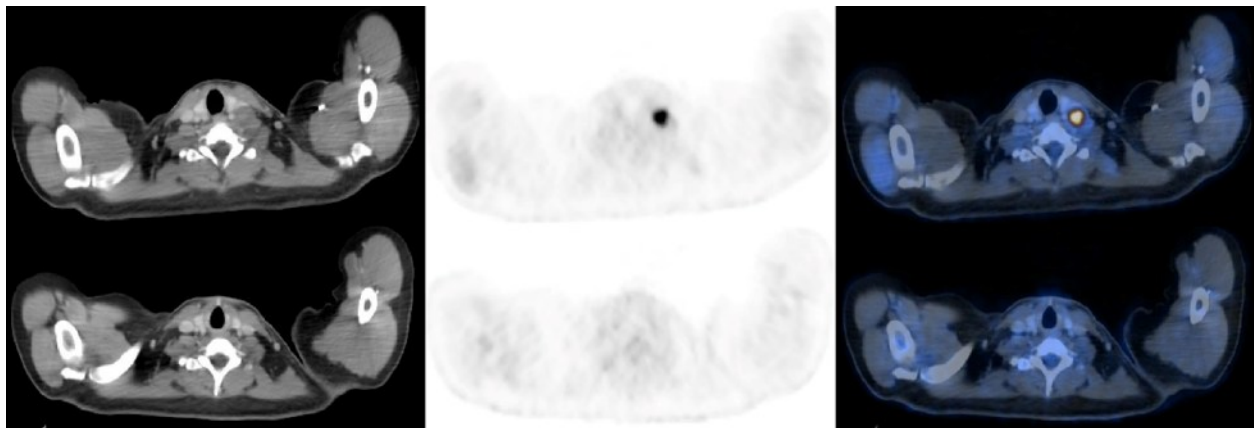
Axial view of the neck, the (A) CT, (B) PET, and (C) fused PET/CT images of the follow-up whole-body PET/CT scan showing resolution of the lesions in the left cervical region. Initial PET/CT scan (1st row) and follow-up PET/CT scan (2nd row) .
